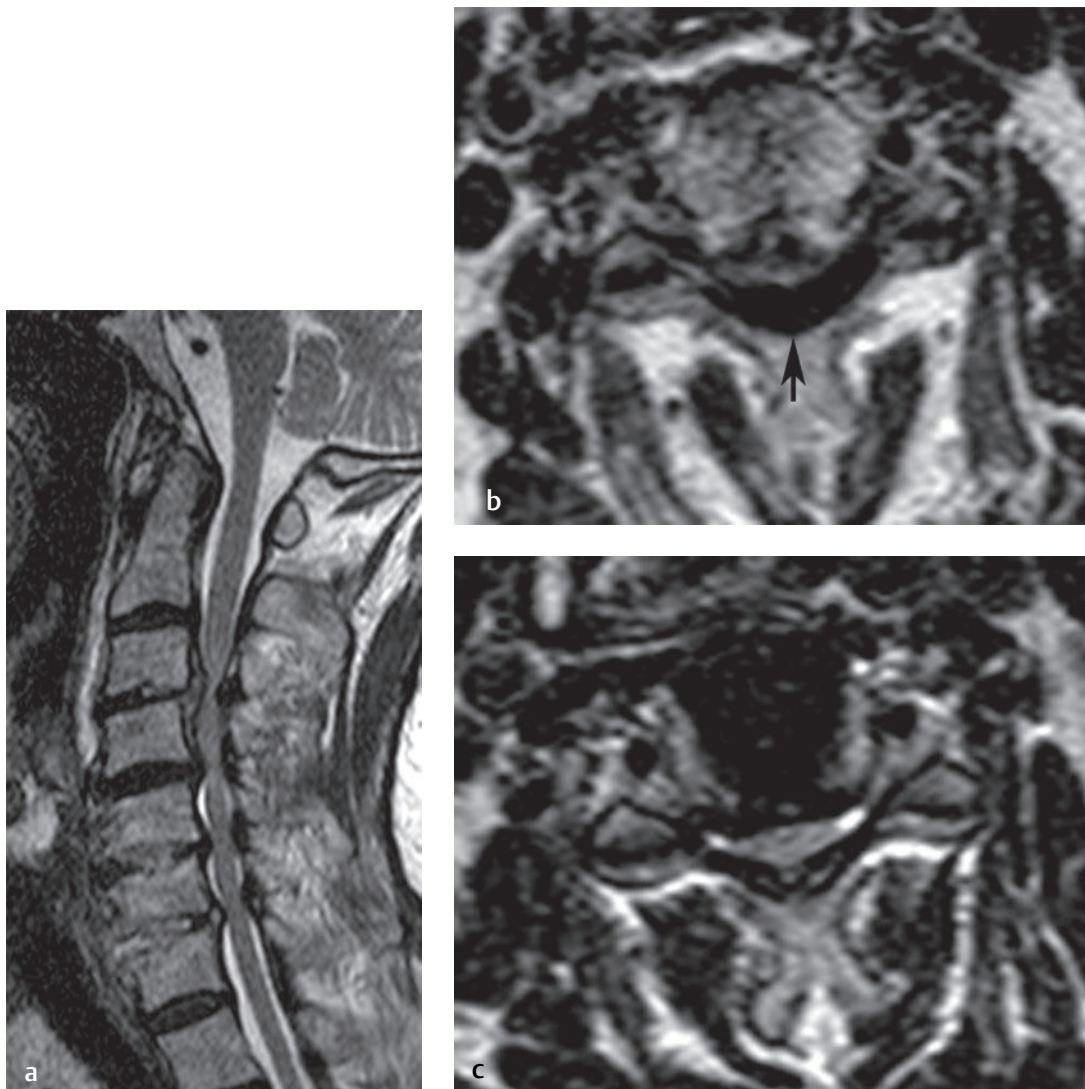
Grading of cervical stenosis: severe. (a) A sagittal T2-weighted image shows severe stenosis at the C3-C4 level and moderate to moderate-severe stenosis at the C4-C5, C5-C6, and C6-C7 levels. (b) An axial image at the C3-C4 level shows very severe stenosis with complete obliteration of the CSF space and compression of the spinal cord to an AP diameter of 2 mm secondary to a central disc bulge and severe ligamentum flavum hypertrophy (*arrow*). (c) An axial T2-weighted image at the C4-C5 level shows severe, but less severe than in (b), stenosis with compression and deformity of the spinal cord with minimal CSF seen in the lateral recesses bilaterally. (Images courtesy of Mesfin A. Lemma, MD.)[†]
